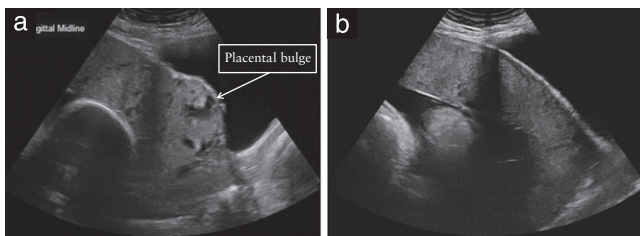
Placental bulge (a) and a normal example for comparison (b) on grayscale ultrasound.
